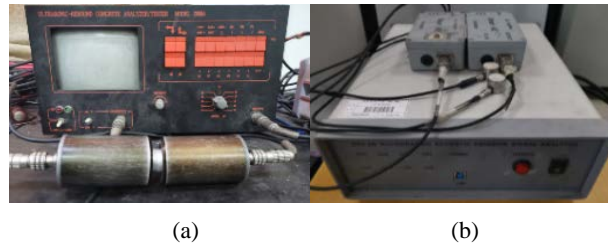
Acoustic testing apparatus. (a)Ultrasonic tester. (b)AE signal analyzer
